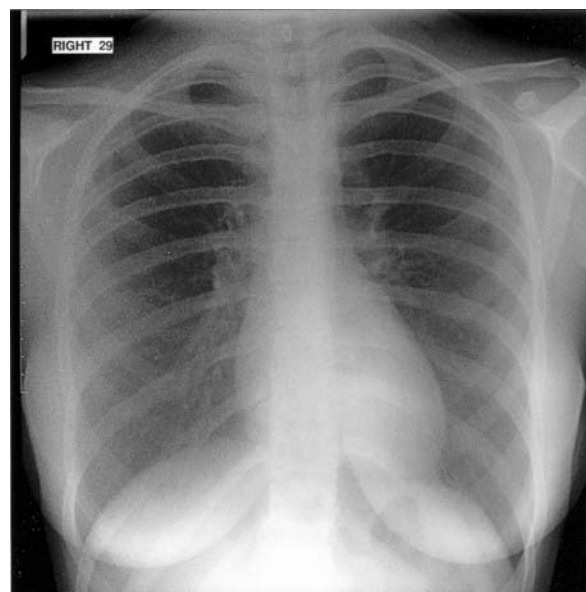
Chest radiograph in the antero-posterior projection, demonstrating a small aortic knuckle and inferior rib notching (fourth, fifth and sixth ribs).
